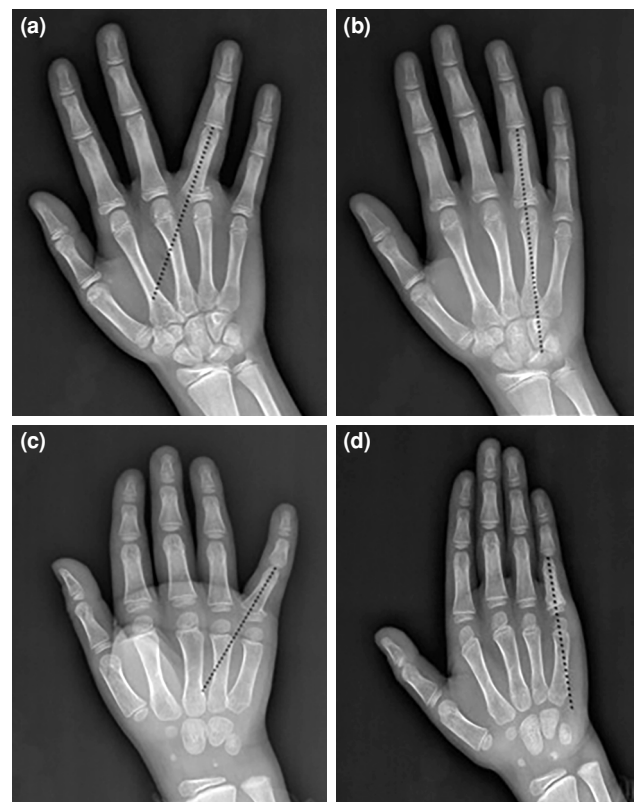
(a, b) Dominant right-hand fourth digit: preoperative X-ray with Campbell's line and postoperative X-ray with Campbell's line. (c, d) Non-dominant right-hand fifth digit: preoperative X-ray with Campbell's line and postoperative X-ray with Campbell's line.
